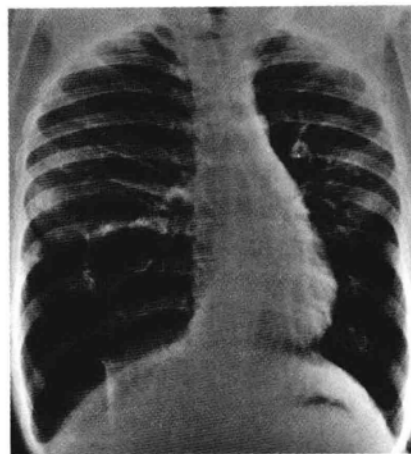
Patient with severe emphysema. Chest radiograph shows hyperexpansion of both lungs with bullous changes at the right lung base and leftward mediastinal shift.
